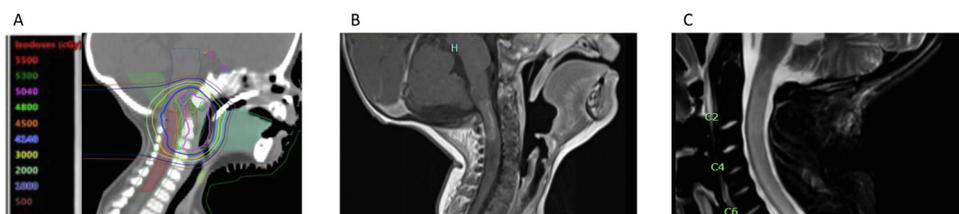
Sagittal images for the 2 cases of grade 5 myelopathy. (A) Focal radiation plan for the first patient (fuschia = 5040 cGy isodose line; blue = 4140 cGy isodose line). (B) T1 gadolinium-enhanced magnetic resonance imaging for the first patient demonstrating patchy enhancement extending from the medulla to the level of C5. (C) T2 magnetic resonance imaging for the second patient, who had been treated with craniospinal irradiation, showing T2 signal abnormality throughout the spinal cord.
